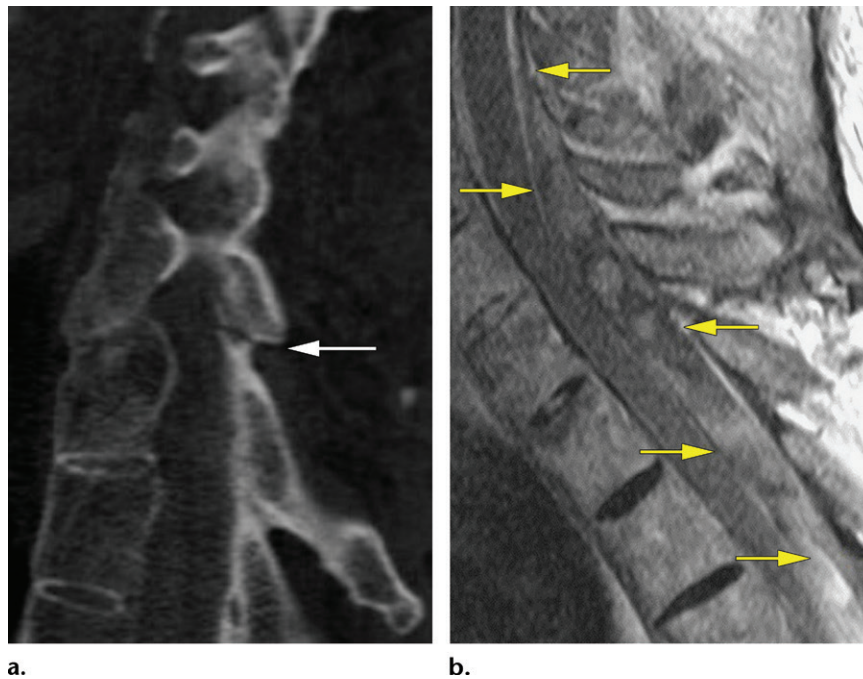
Dorsal epidural hematoma in an 89-year-old man with AS who presented with neck pain after a fall. (a) Sagittal reformatted CT image shows a nondisplaced C7-T1 right facet fracture (arrow). Because of the patient's known AS diagnosis, neck pain, and trauma, MRI was performed. (b) Sagittal T2-weighted MR image shows an extensive C3-T3 dorsal epidural hematoma (arrows) adjacent to the thecal sac.
